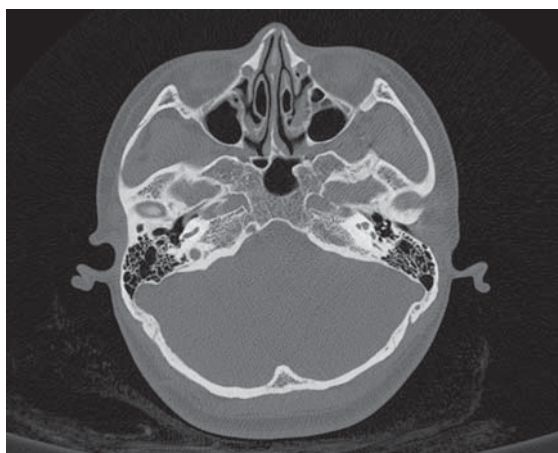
CT scan results of case No. 208 (female, 16 years old).
